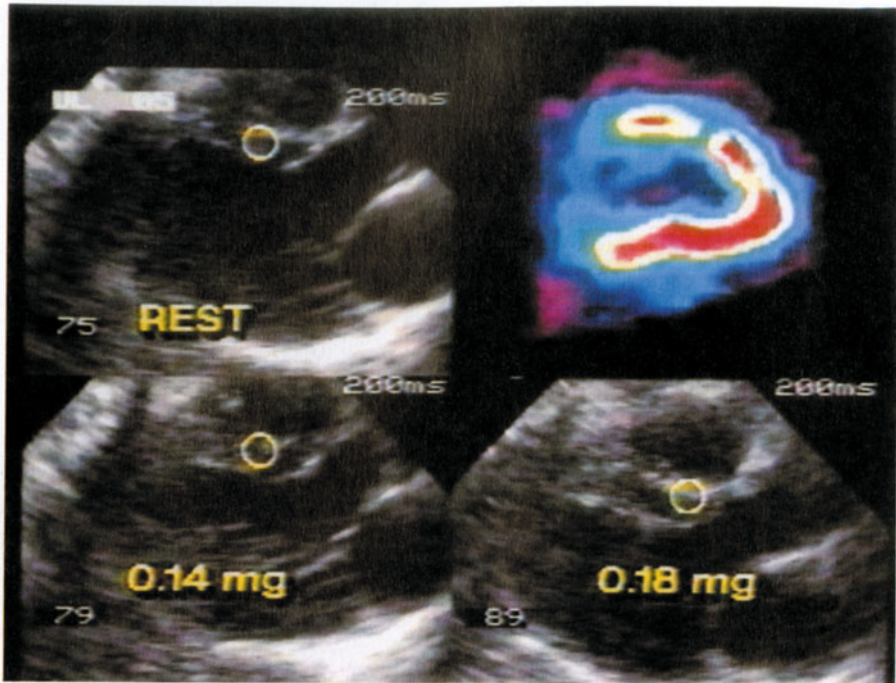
Results of adenosine stress echocardiography and MIBI-SPECT in a patient with left bundle branch block and normal coronary arteries. Scintigraphy (upper right) reveals an anteroseptal perfusion defect. Systolic images at rest and during adenosine stress demonstrate normal myocardial thickening at the same site (circled).
